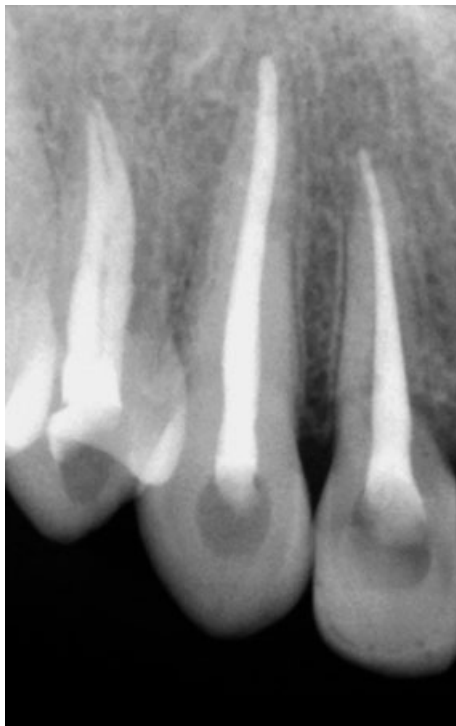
Radiographic view 3 years later.
